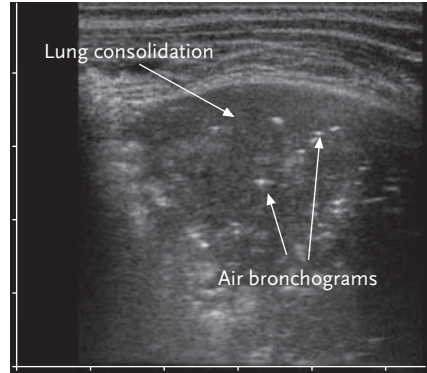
Typical ultrasound appearance of pneumonia in children.
